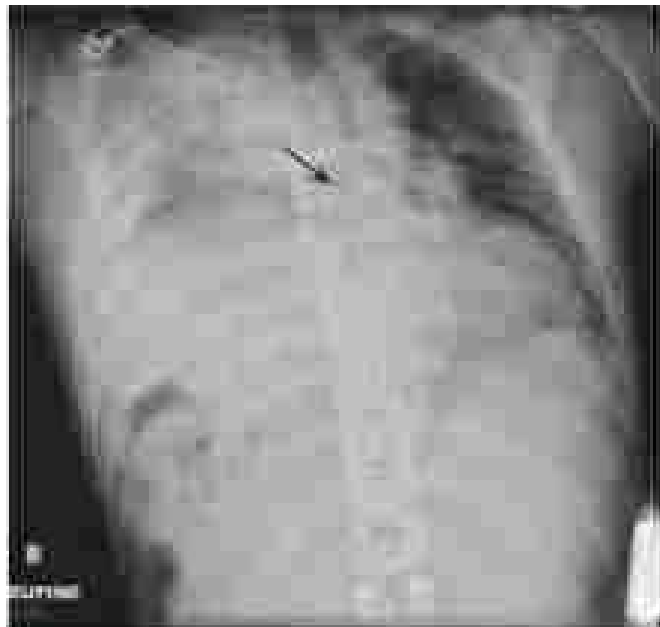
Portable chest radiograph. Near complete opacification of the right hemithorax with only partial aeration of the anterior segment of the right upper lobe. There is collapse of the bronchus intermedius (arrow) and associated collapse of the right lower lobe. There is shift of the trachea, main and cardiac to the left. Fluid is present along the right upper pleural surface, consistent with a hemothorax. The right hemidiaphragm is markedly elevated with indistinct margins. Although volume loss secondary to a collapsed lung also causes elevation of the diaphragm, presence of any unilateral mechanical shift suggests a space-occupying mass and favors the diaphragmatic rupture. (From Finkelstein et al.¹⁷ with permission: *Diaphragmatic Injury: Imaging from Chest Trauma*, *Emerg Med*, vol. 2007, 1(1):45-7)
